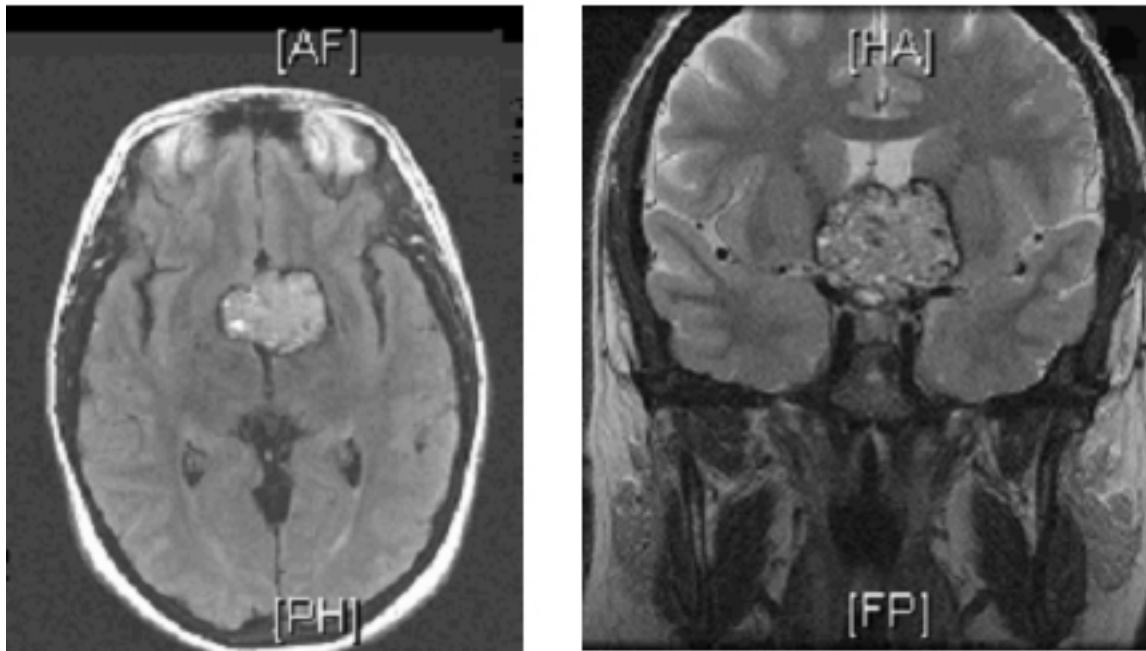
MRI brain. Transverse (left) and frontal (right) views. Large 3.0 cm x 4.9 cm x 3.4 cm heterogeneous mass in the suprasellar cistern, displacing the optic chiasm and pituitary infundibulum.
